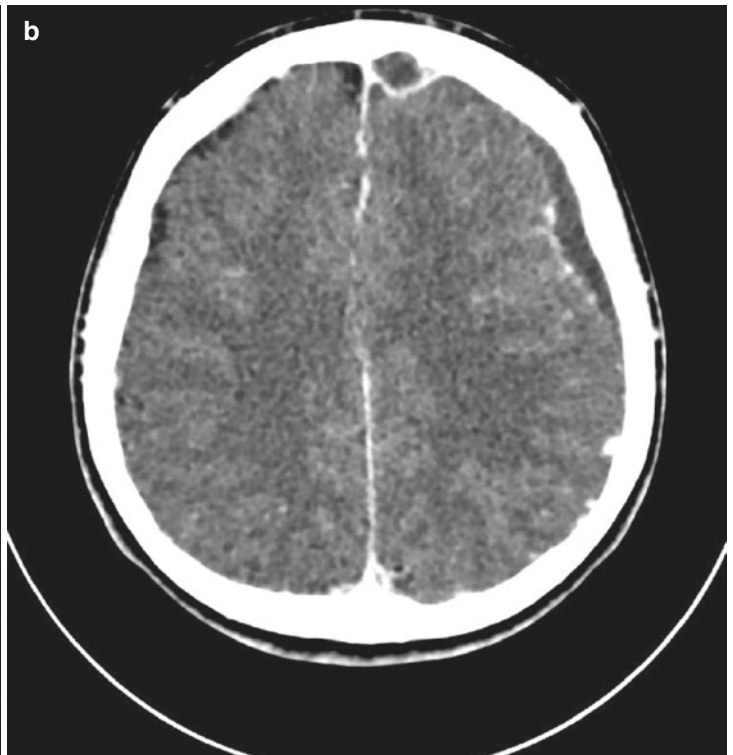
Sinusitis and intracranial empyema secondary to dental abscess. (a) Coronal reconstructed CT image reveals bone destruction and a collection around the root of an upper left molar. This collection
